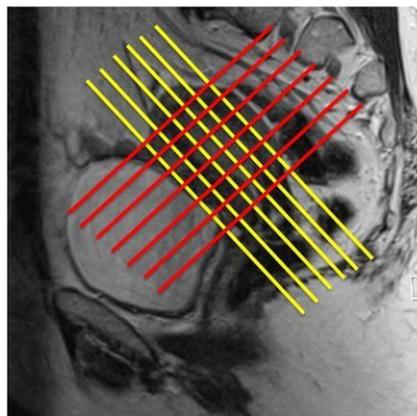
MRI scanning plans. Sagittal Turbo Spin Echo (TSE) T2-weighted image (TR/TE3200/82 ms) showing the correct scanning plans: para-axial (red lines) and para-coronal (yellow lines) images should be acquired orthogonal to the endometrial cavity.⁽²⁸⁾
